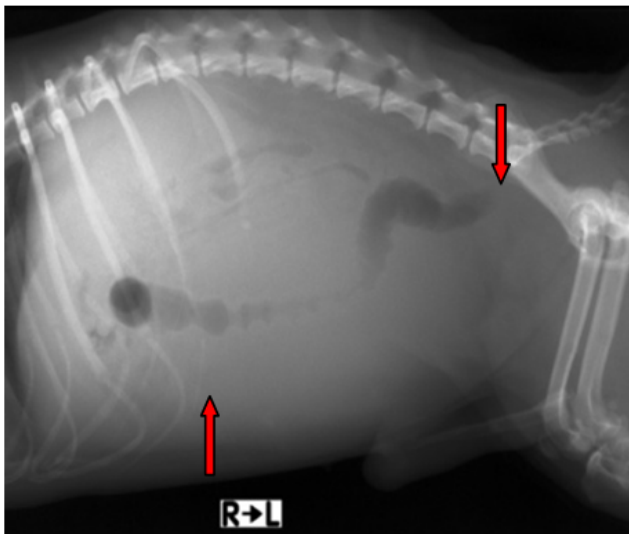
Radiography revealed cranial displacement of urine filled urinary bladder and caudal displacement of colon, which was slightly compressed by the prostate
